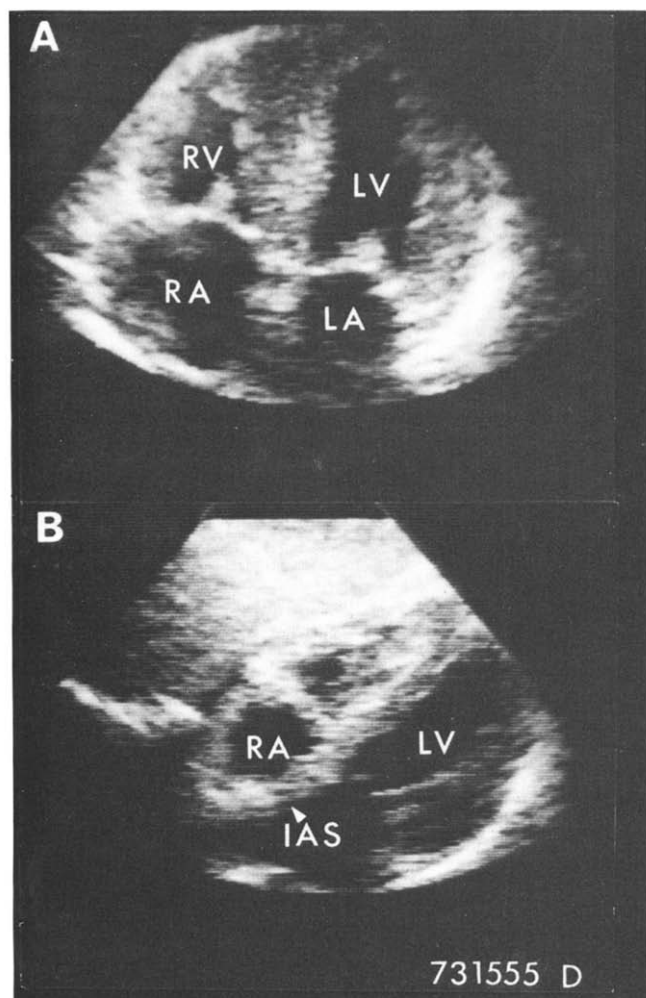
Four chamber (A) and subcostal (B) two-dimensional echocardiograms of a patient with hereditary amyloidosis. The four chamber view demonstrates the markedly thickened walls and valves. There is also thickening of the interatrial septum (IAS) noted on the subcostal examination. The cardiac walls have a "stippled" appearance which may be characteristic of an infiltrative cardiomyopathy. (Reprinted from Feigenbaum H [10], with permission.)
